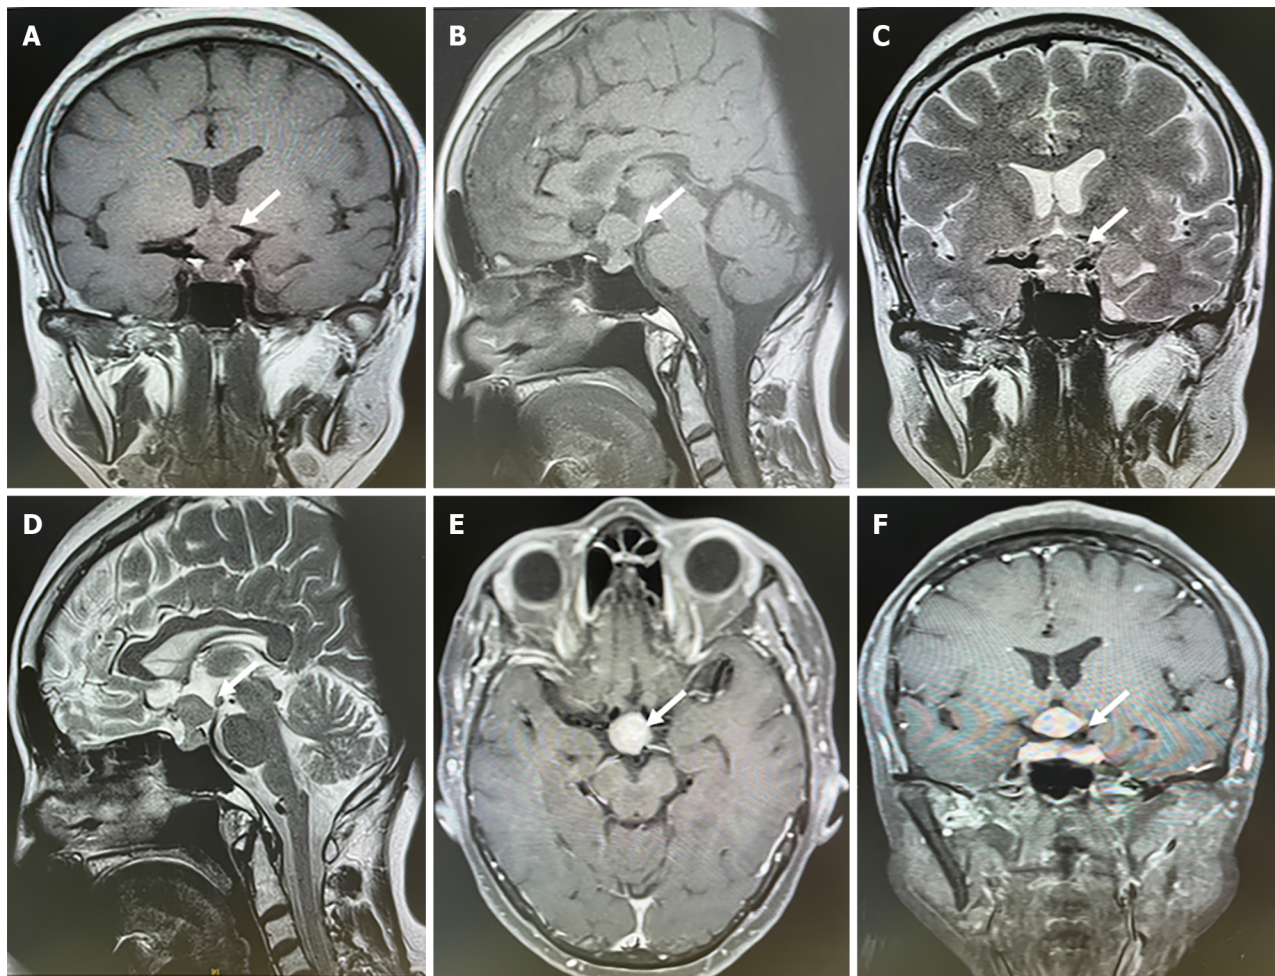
Sellar magnetic resonance imaging showed a sellar lesion related to carotid artery. A-D: The lesion located in the sellar region presented with an isointense signal on T1 and T2-weighted images and could see hourglass sign; E and F: The lesion was intensified homogenously enhanced after contrast magnetic resonance imaging.
